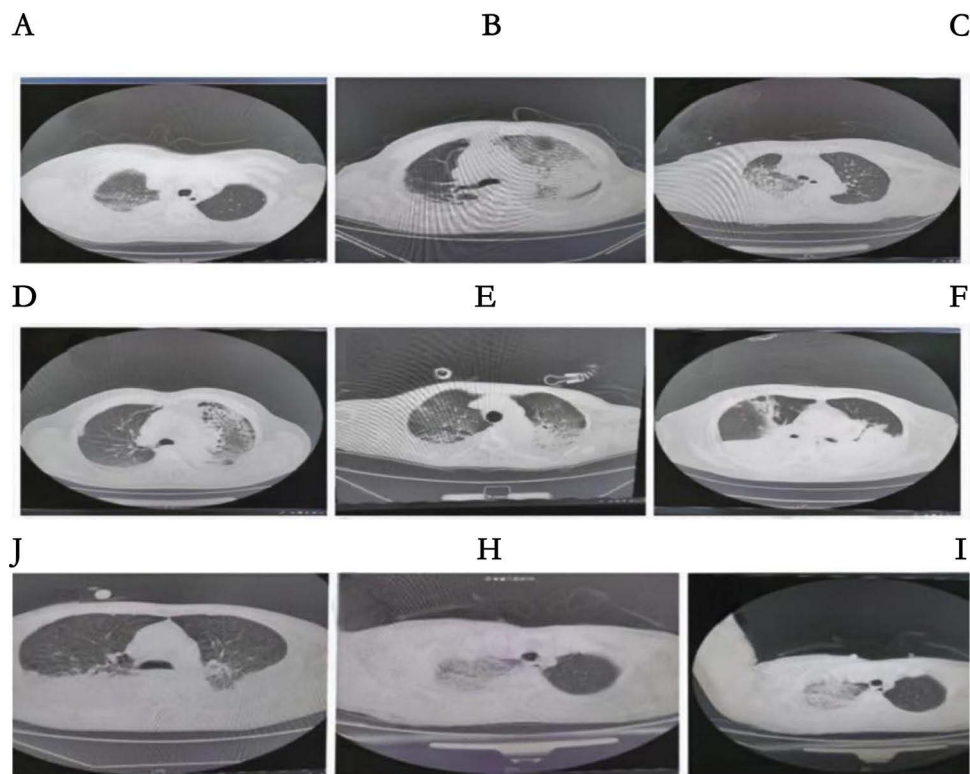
Computed tomographic scan showing markedly pleural effusion in 9 patients with *C. psittaci* pneumonia (A) a 70-year-old man, hospitalized due to fever and cough for 4 days. (B) a 69-year-old man, hospitalized due to fever for 4 days. (C) a 70-year-old woman, hospitalized due to fever for 3 days. (D) a 73-year-old man, hospitalized due to fever, cough, and Expectoration for 7 days. (E) a 67-year-old woman, hospitalized due to fever and Chills for 8 days. (F) a 79-year-old woman, hospitalized due to fever and cough for 13 days. (G) a 72-year-old man, hospitalized due to fever and Chills for 10 days. (H) a 49-year-old woman, hospitalized due to fever for 20 days. (I) a 48-year-old woman, hospitalized due to fever for 5 days.
